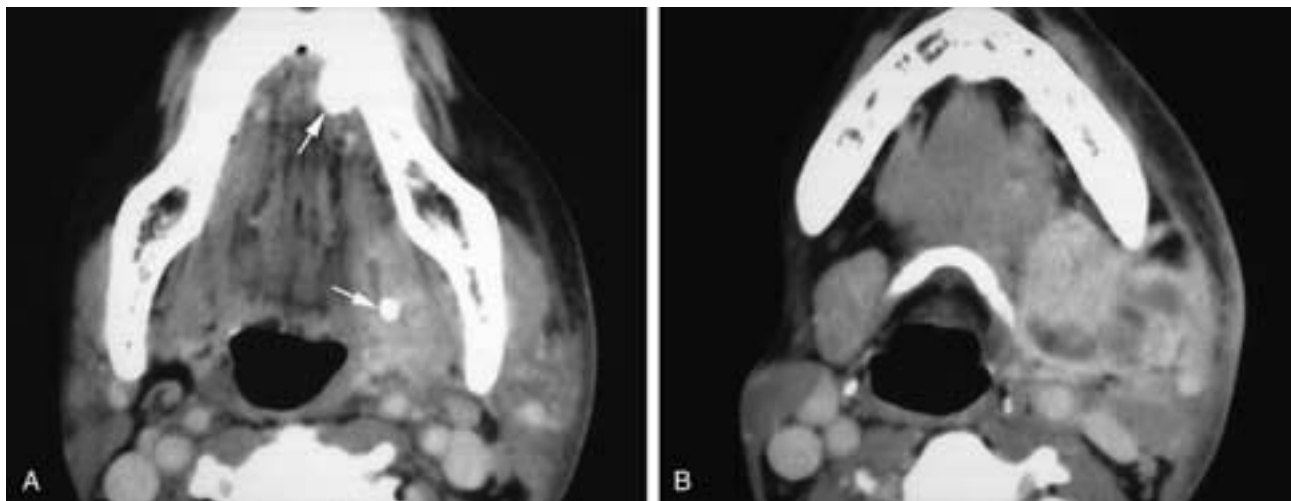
Axial contrast-enhanced CT scans (A, B) show two calculi in the left submandibular gland system (arrows). The stone at the hilum of the gland has caused an acute sialadenitis with a cellulitis. In B, an abscess is also seen around the gland. The formation of an abscess in acute submandibular sialadenitis is uncommon, and testing found this male to be HIV positive. This patient had submandibular sialolithiasis, sialadenitis, cellulitis, and an abscess.
